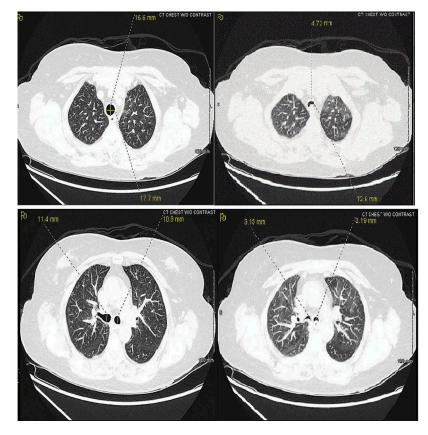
Axial noncontrast computed tomography (CT) during inspiration (left panels) showing a normal tracheal and both main bronchi lumen. During expiration, axial noncontrast CT (right panels) showing thin crescent-shaped ('frown sign') tracheal lumen and both mainstem bronchi.
